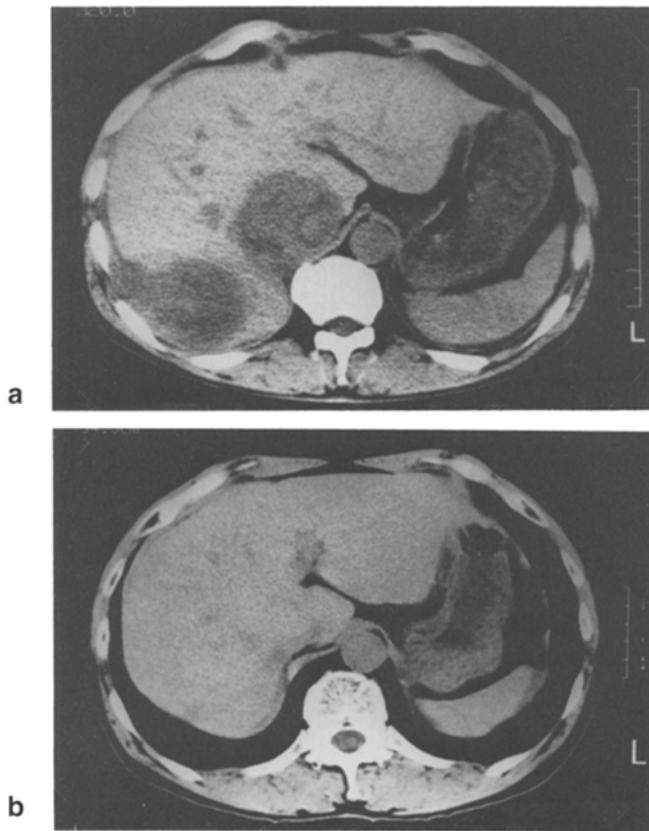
a, b. CT images obtained a prior to and b after EAP-TAE therapy in a 53-year-old man (a) Two nodules are visible in the right hepatic lobe, and the IVC is markedly depressed (b) The two nodules have decreased greatly in size and almost disappeared
